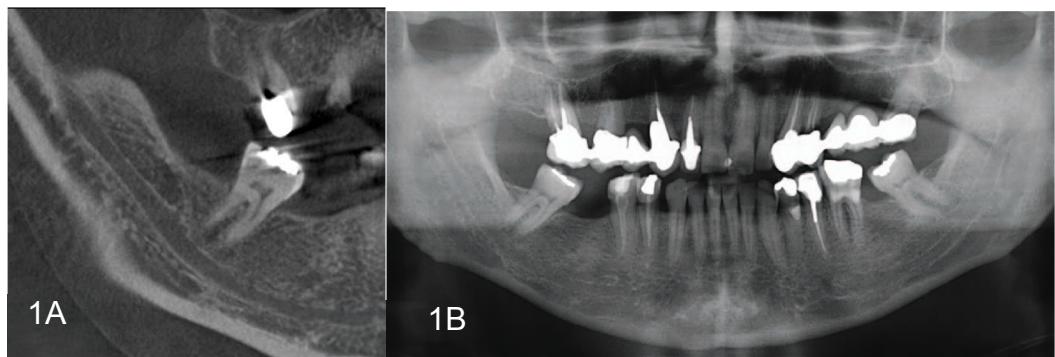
Sagittal reconstruction showing a RMC (right side); 1B. RMC could not be identified on panoramic radiography
